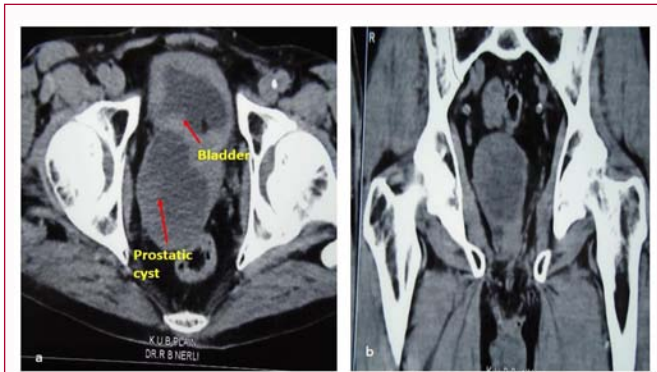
a) CT scan showing a cystic mass within the prostate of the size 6.5X5.4 cm. b) The content is not clear and the cyst wall shows areas of solid mass.
